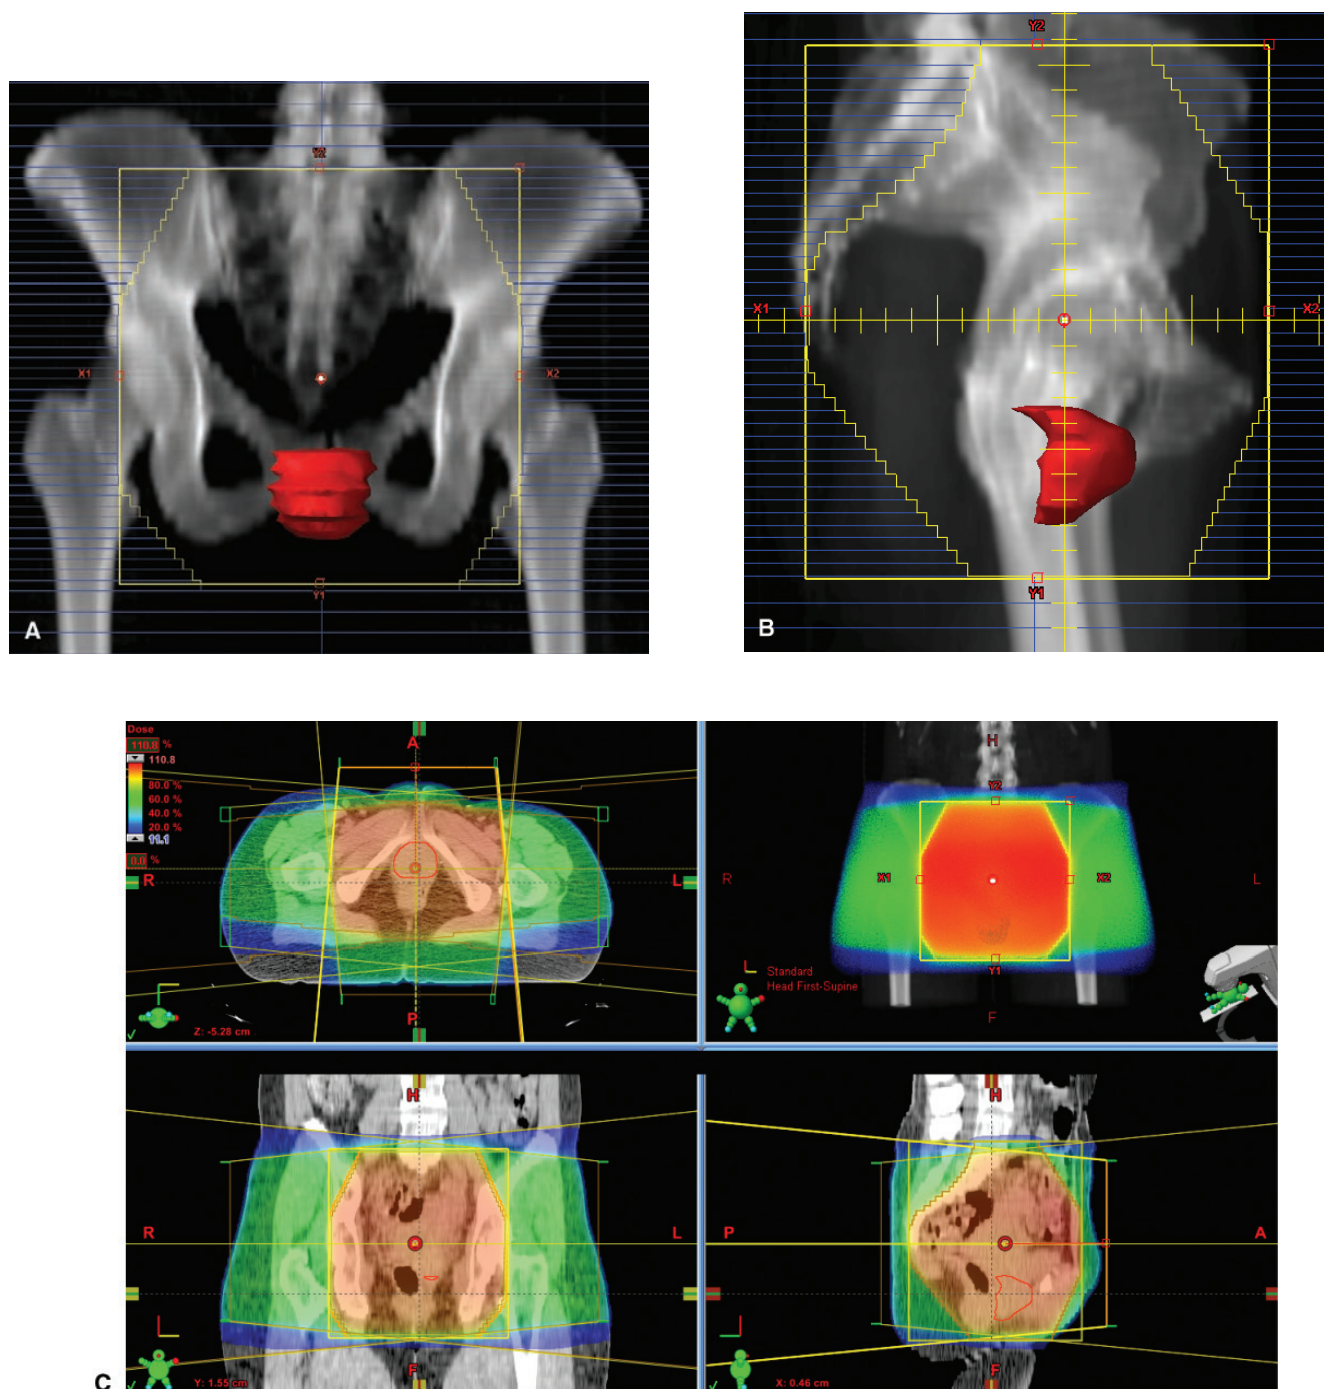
Proximal third vaginal cancer; invasive squamous cell carcinoma, with mid-third of the vagina squamous cell carcinoma *in situ*, without involvement of inguino-femoral nodes. Digital Reconstructed Radiographs (DRRs). A: AP/PA whole pelvis fields. B: Right/Left lateral whole pelvis fields, intended to treat the entire length of the vagina. C: Axial, sagittal, and coronal isodose distributions.
